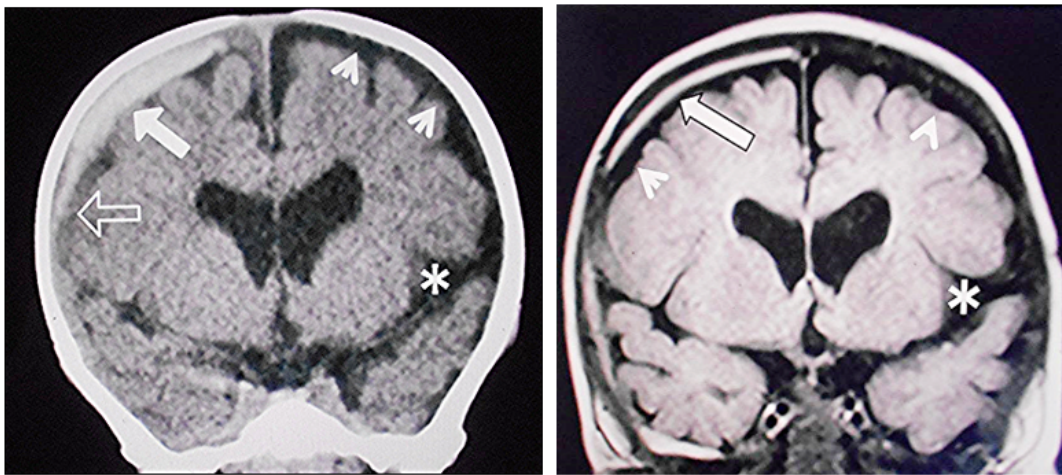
Case 1 (No.7) Male aged 7 months. Left: Coronal CT revealing a mixed-density SDH with high density in the frontal (arrow) area and low density (open arrow) in the temporal area on the right side. Note the enlarged subarachnoid spaces (arrowheads) and the LSF on the left side. (asterisk). Right: MRI (FLAIR, coronal view) at 14 days post-presentation at the outpatient clinic showing a decrease in the volume of the SDH around the right cerebral hemisphere. (arrow) Note the BESS (arrowheads) and the LSF on the left side. (asterisk).
